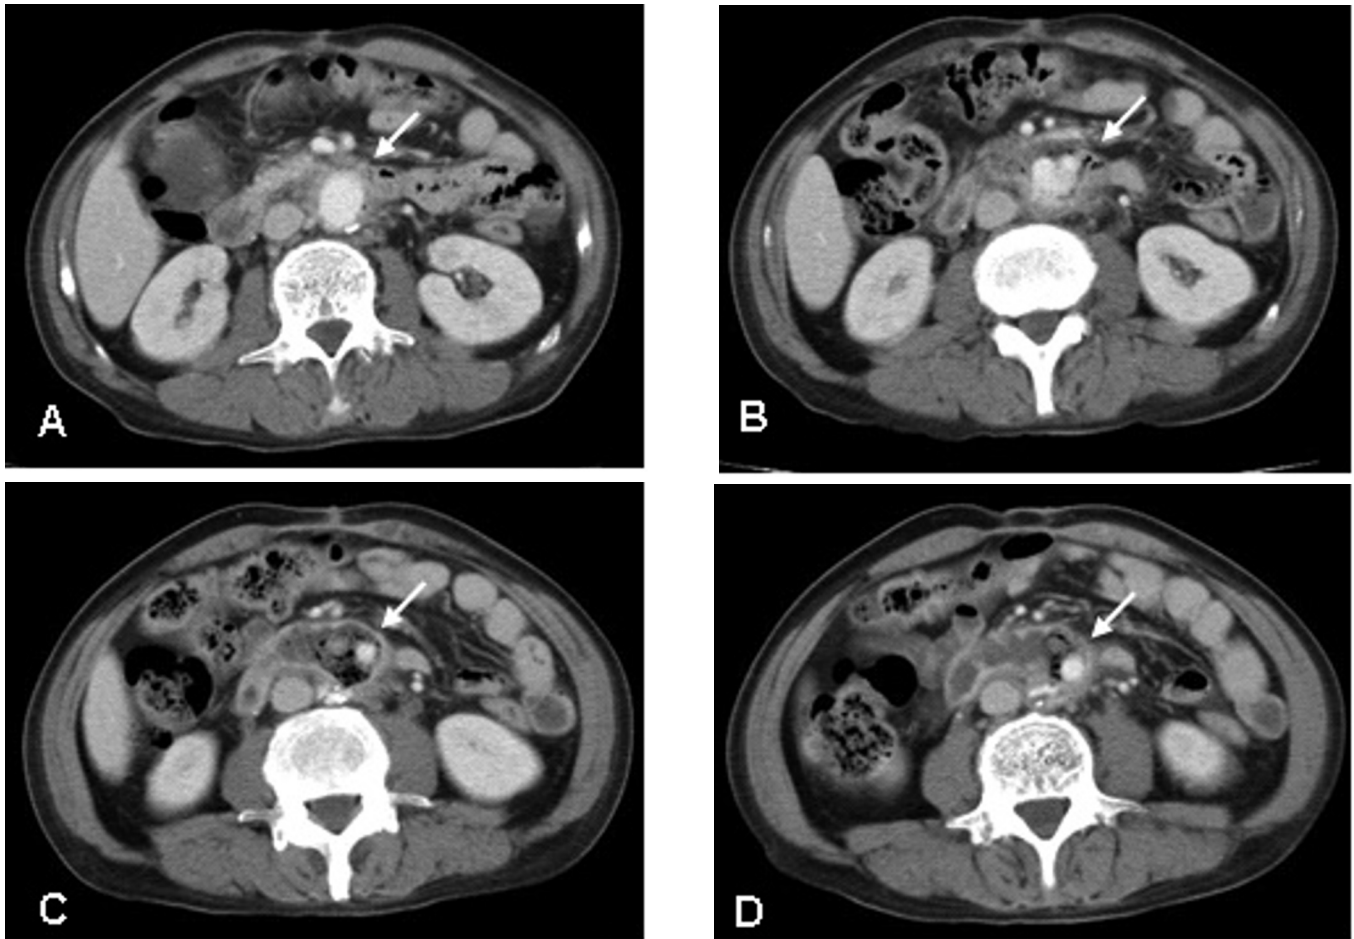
Axial CT images at four levels (A-D). The prosthesis penetrates the third duodenal segment, and the right graft limb is occluded (white arrows).
